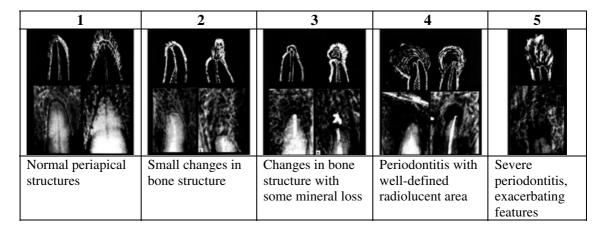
Visual references of the periapical index (PAI) (Ørstavik et al. 1986).
